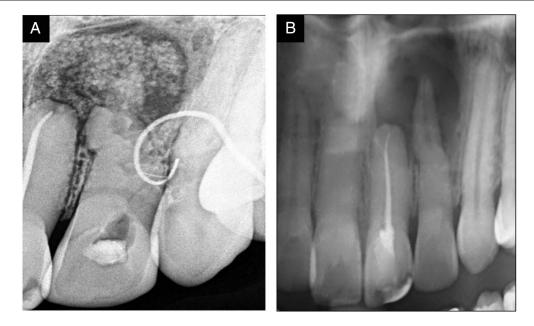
Preoperative diagnostic investigations. (A) The preoperative RVG shows a sinus tract tracing with gutta-percha pointing at tooth #10. (B) The preoperative orthopantomogram showing a calcified canal and dilacerated root in tooth #10 and faulty obturation in tooth #9. Note the periradicular radiolucency around teeth #9 and #10.
